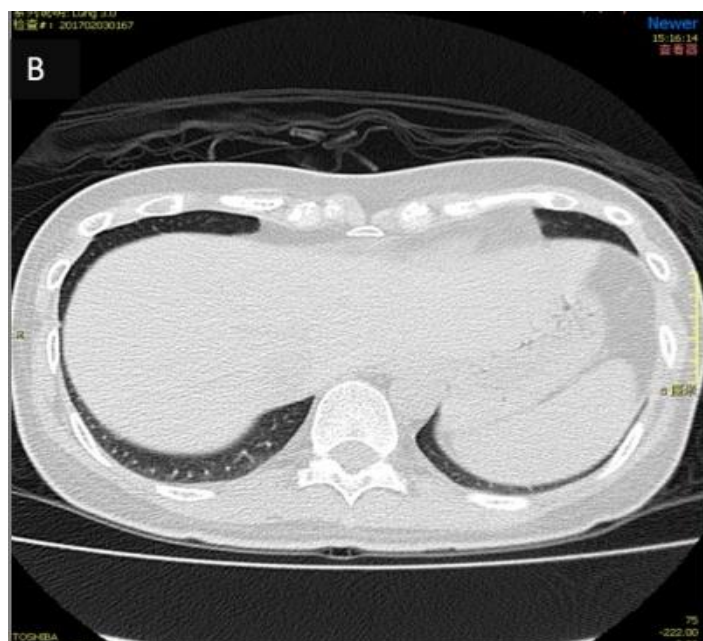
Chest CT (after chemotherapy)
